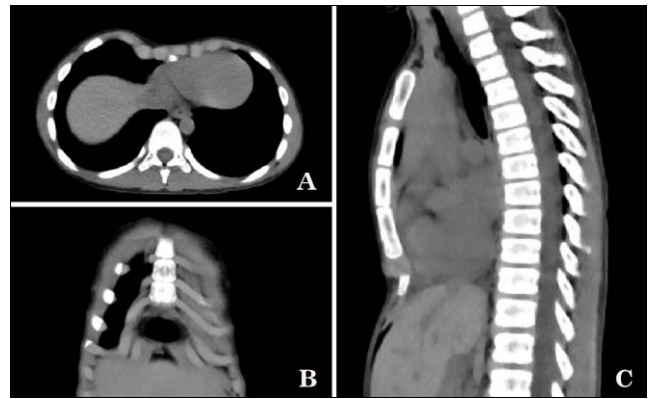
Chest CT scan image. The anterior chest wall is obviously sunken, and the heart is compressed and moved to the left
